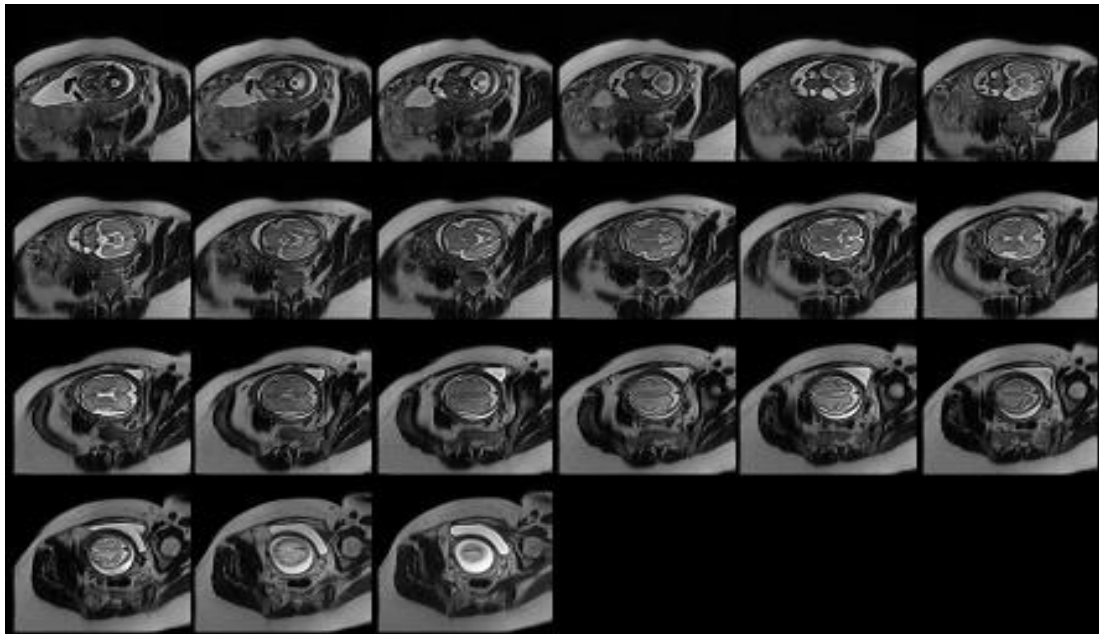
Fetal normal brain MRI (GW 20)
